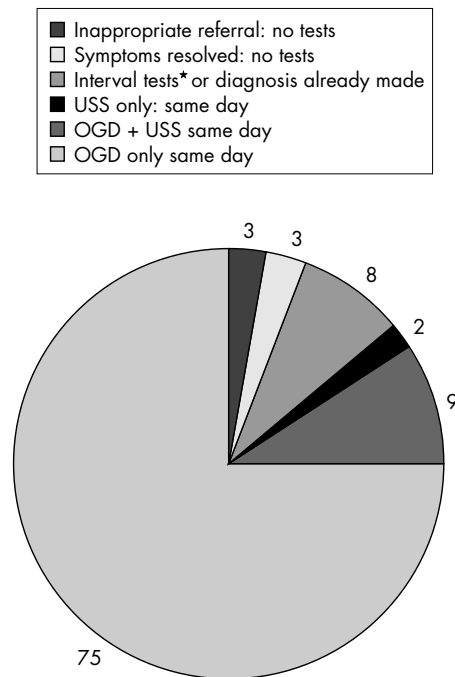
Investigations arranged through the one stop service; *three patients unfit for one stop tests, one on proton pump inhibitor, one colonoscopy required + gastroscopy (OGD), one gallstones on GP ultrasound (USS), one declined OGD (referred for barium meal), one probably functional symptoms.
